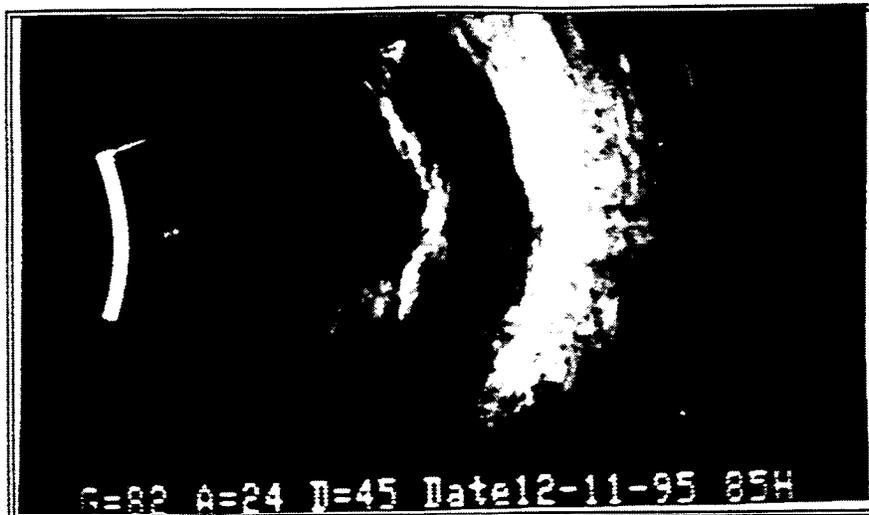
Ultrasound Image of Detached Retina
